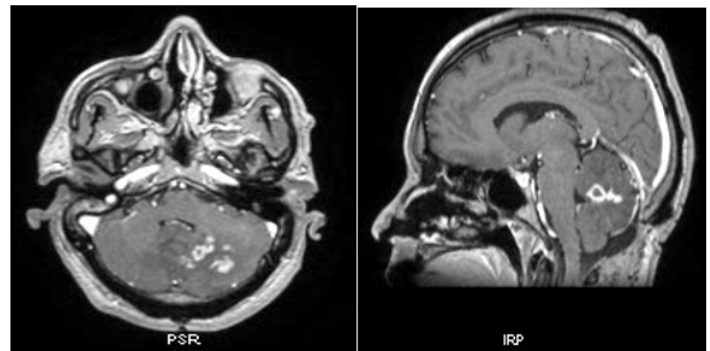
Brain Magnetic Resonance Imaging (MRI) showing a large (4*3 cm) well-defined, vermian lesion extending to the left cerebellar hemisphere with corresponding tuberculomas.
